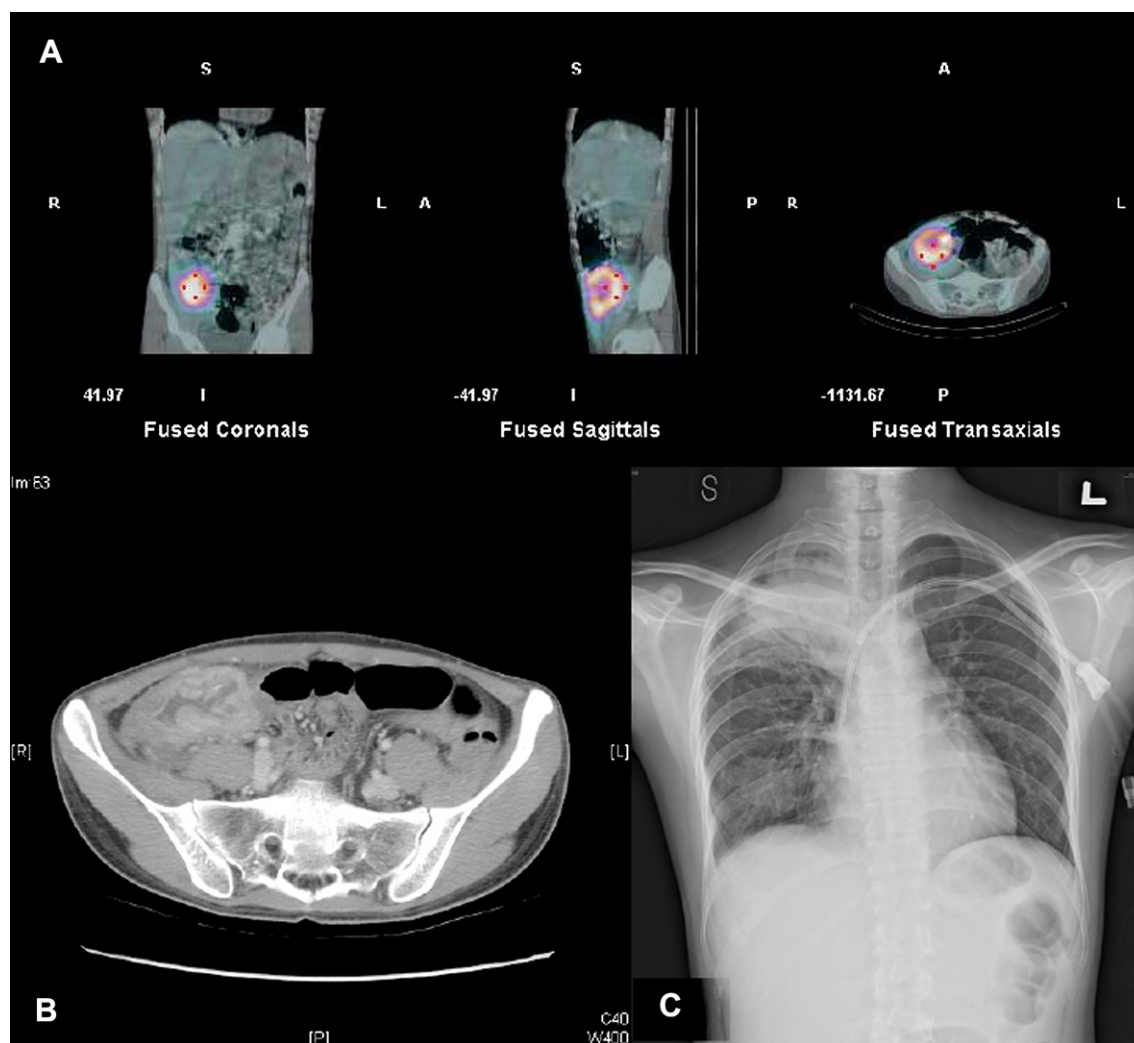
(A) Gallium-67 scan for inflammatory activity reveals a focal area of increased uptake of radioactivity in the right lower abdominal region, which is suspected to be regional peritonitis (SPECT/CT images). (B) Pelvic CT with contrast medium administration shows marked cecal wall thickening with pericolic inflammatory stranding. (C) Chest radiography reveals patchy infiltrations in the right upper and lower lung fields. An air bronchogram is also noted in the upper lung field. CT = computed tomography; SPECT = single photon emission computed tomography.
